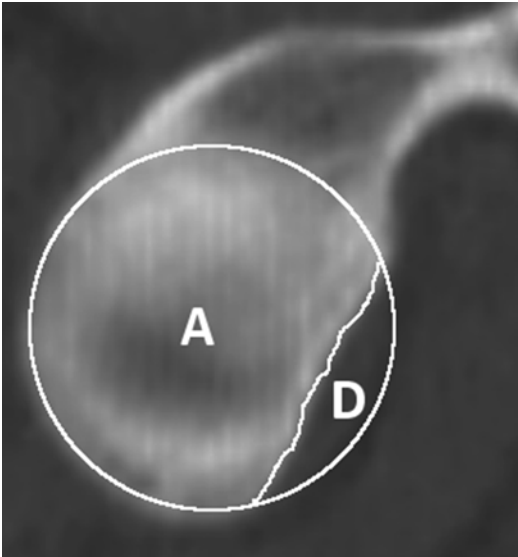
“Pico” method for measurement of glenoid bone defect based on the use of the circle method on 2D CT scans by comparison with the contralateral healthy shoulder (A area of the inferior glenoid of the contralateral healthy shoulder. D area of the glenoid bone defect on the affected shoulder)
